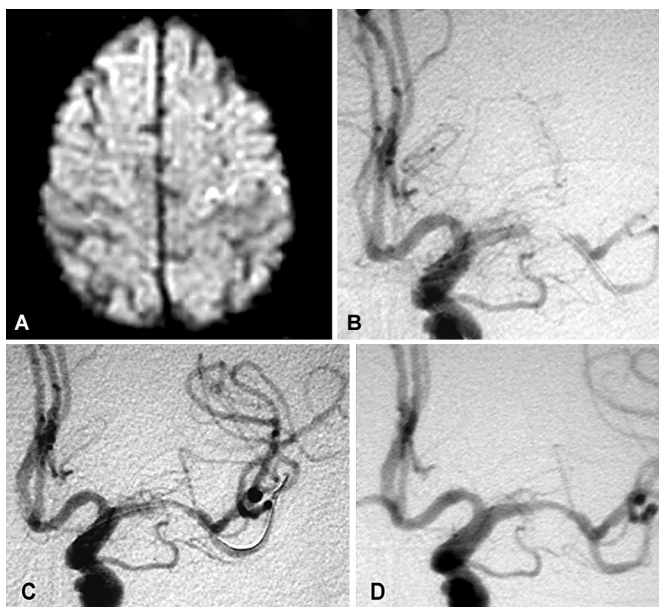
A, diffusion-weighted magnetic resonance imaging scan showing a small watershed infarction in a 61-year-old woman with a 4-week history of progressive right hemiparesis and aphasia. B, cerebral angiogram showing a string of the left middle cerebral artery filling. C, cerebral angiogram showing excellent luminal improvement after M1 dilation with a 1.5×15 -mm angioplasty balloon. Some haziness of the lesion can be appreciated, which is consistent with plaque disruption. D, cerebral angiogram showing the final result after deployment of a 2.5×15 -mm Wingspan stent (Boston Scientific, Fremont, CA), across the stenosis. Excellent luminal reconstruction can be seen.
